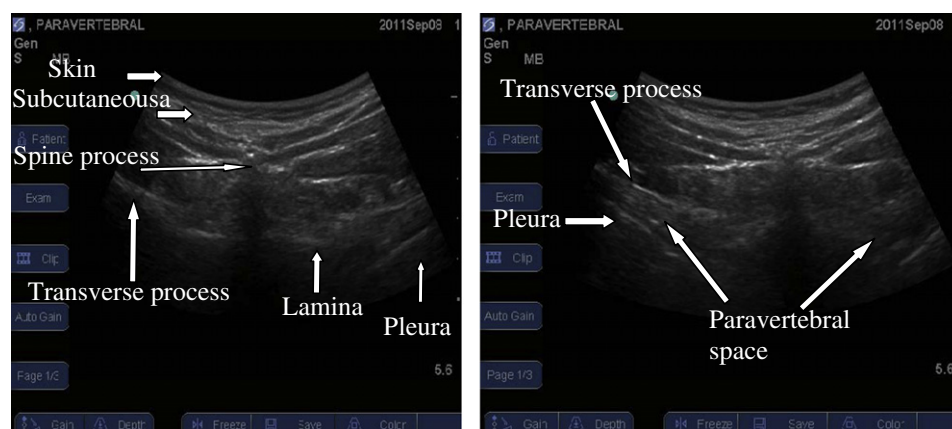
Ultrasound image of 3rd thoracic vertebra and paravertebral space.
